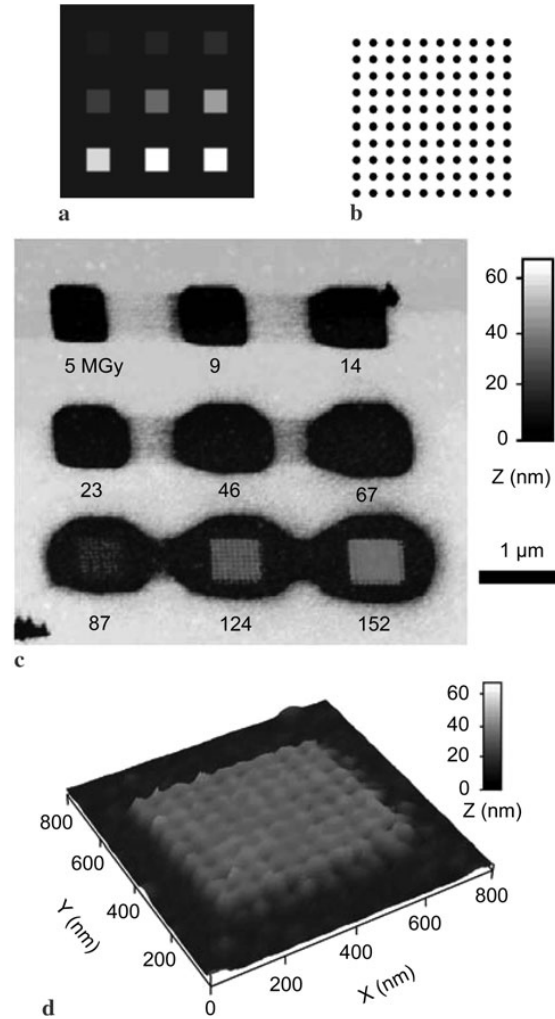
(a) The pattern used to drive the sample positioning stages relative to the focal point consists of nine 600×600 nm areas. (b) Each square in (a) is composed of 10×10 individual exposures spaced 60 nm center to center. (c) AFM image of the pattern directly written in PMMA with focused 300 eV monochromatic X-rays after development. (d) Expanded three dimensional view of the eighth area in (c). The measured center to center spacing of the crosslinked PMMA mounds is 60 ± 5 nm
